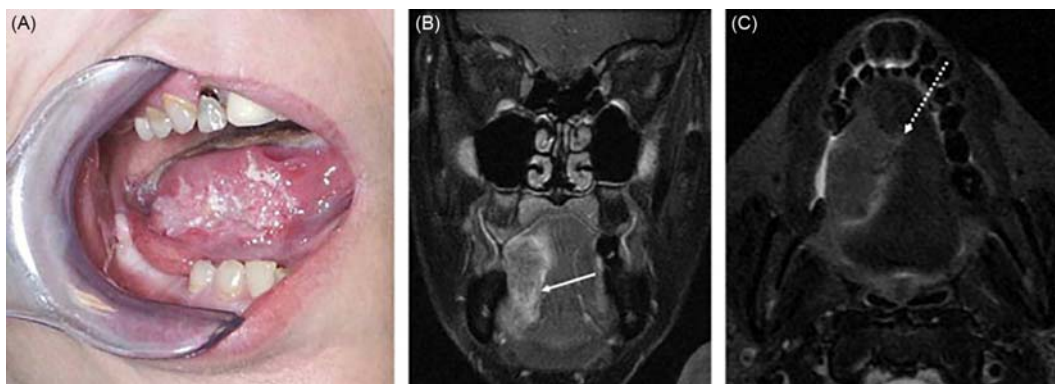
Right lateral tongue squamous cell carcinoma crossing midline, with involvement of the genioglossus muscles. (A) Photograph shows an extensive area of mucosal irregularity and leukoplakia involving the right lateral tongue. The patient was unable to move the tongue due to tumor infiltration and pain. Coronal T1-weighted postcontrast fat-saturated (B) and axial STIR (C) images show a T2-hyperintense enhancing mass in the right tongue. The coronal image shows inferior extension into the floor of mouth/sublingual space (*solid white arrow* in B) and medial involvement of the genioglossus muscle. The axial image shows extension across the midline (*dashed arrow* in C). From Hagiwara, M., Nusbaum, A., and Schmidt, B. L. (2012). MR assessment of oral cavity carcinomas. *Magnetic Resonance Imaging Clinics of North America* 20(3), 473–494.
